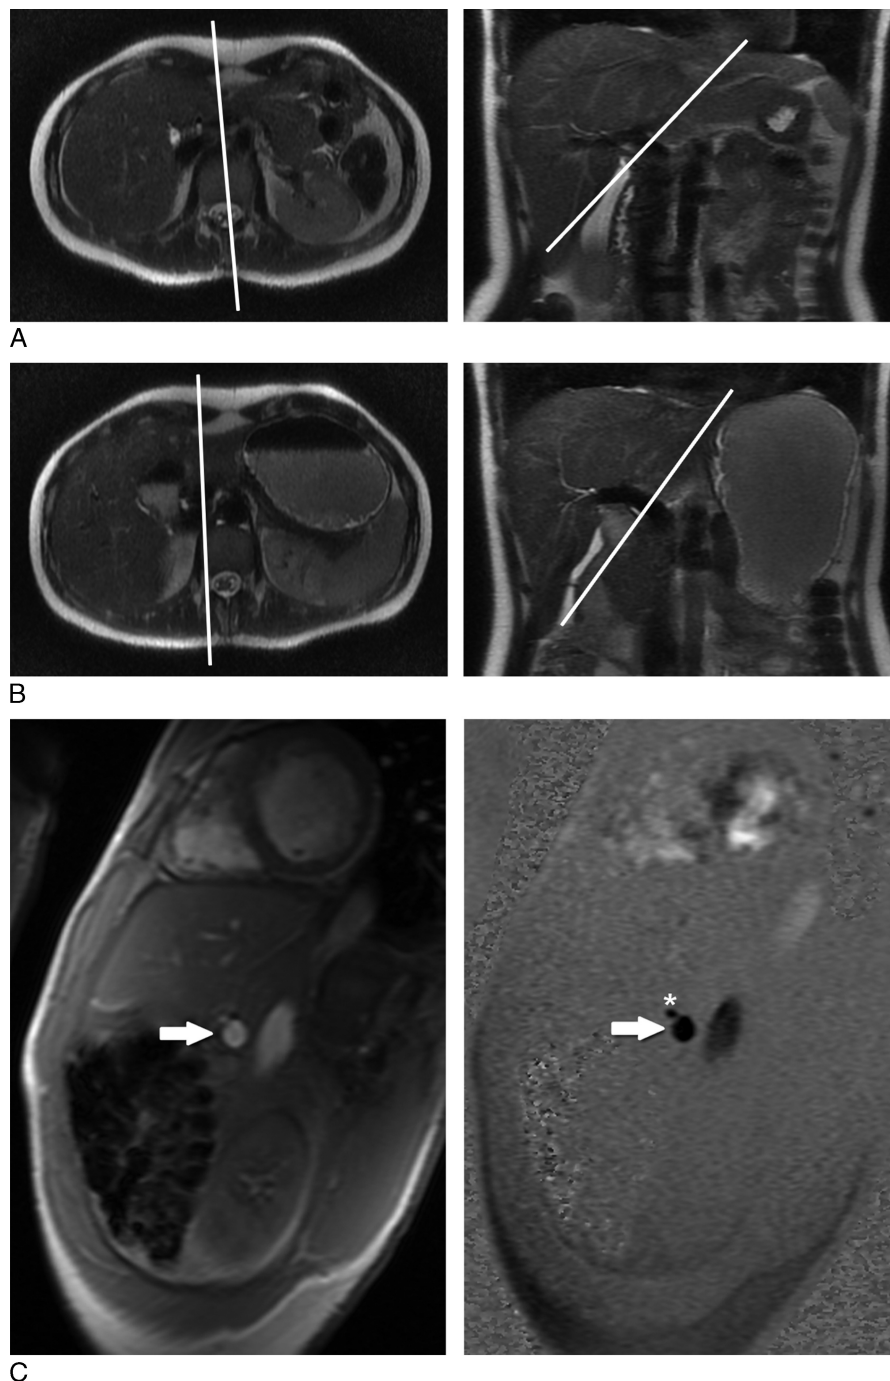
Axial and coronal T2-weighted single-shot fast spin echo morphological scout images after fasting for at least 8 hours (A) and after a protein-rich meal with a filled stomach (B). C, Multiphase gradient-echo magnitude (left) and phase-contrast (right) images acquired for measurement of blood volume flow in the portal vein (arrows). The imaging plane in C was oriented perpendicular to the portal-vein long axis (white lines in A and B). C, The common hepatic artery, located above the portal vein, is marked with a star.
